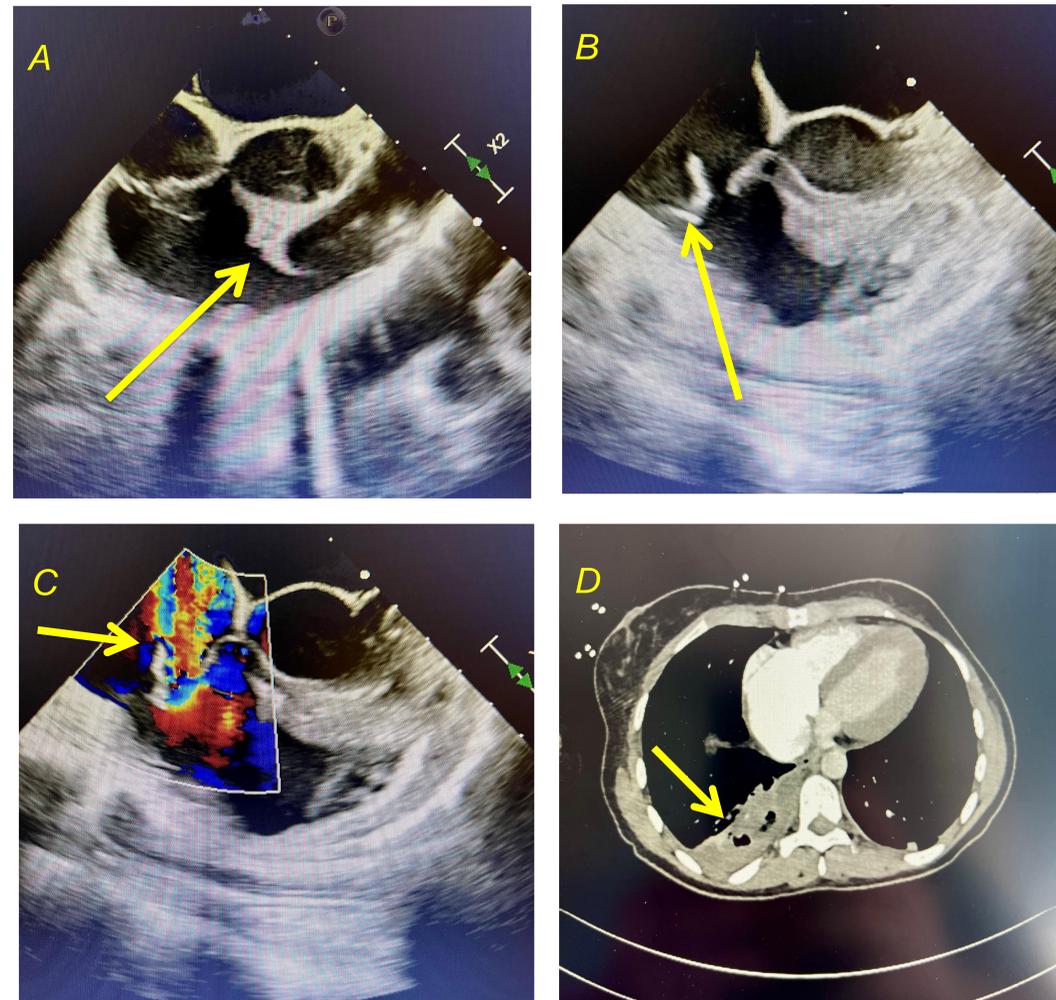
TEE showing vegetation on right ventricular infundibulum/ RVOT (arrow). Image B: TEE showing slender vegetation on anterior leaflet of tricuspid valve (arrow). Image C: Severe tricuspid regurgitation jet noted on TEE (arrow). Image D: CT chest angiogram showing dense consolidation in right lower lobe (arrow). There were also other areas in bilateral lungs showing solid and cystic appearing nodules consistent with septic emboli.
